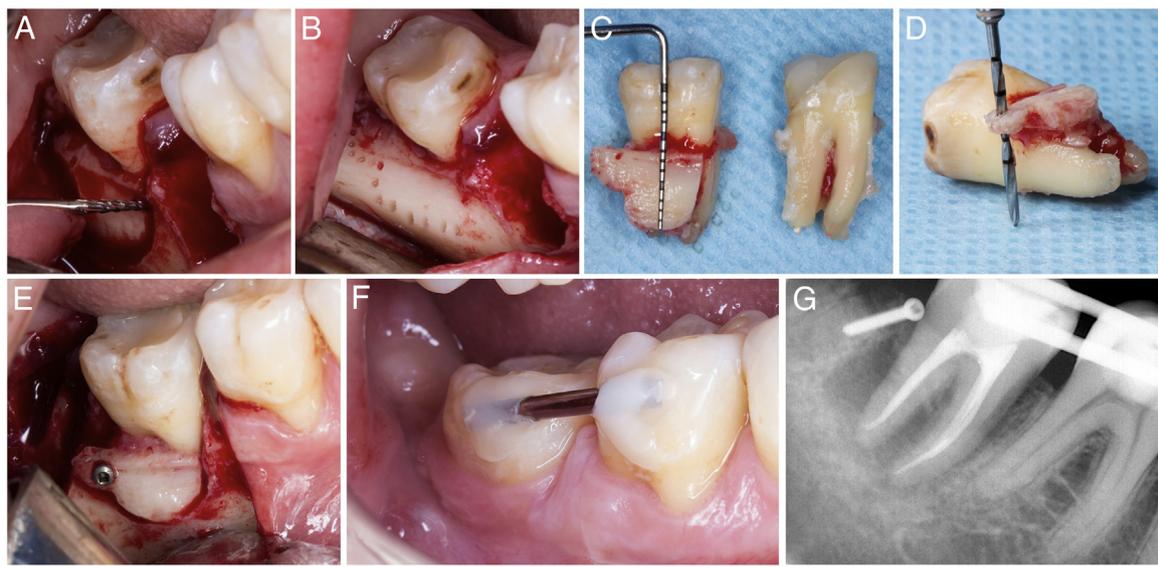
(A and B) A precise and calculated osteotomy guided by the CBCT image of the cortical bone of tooth #32. (C) A comparison of size between teeth #31 and #32. (D and E) The block was fixed to the recipient socket with an osteosynthesis screw. (F) A double resin wire splint. (G) A periapical radiograph confirming the correct position of the tooth after replantation and splinting. The transplanted tooth was positioned below the occlusal plane.
